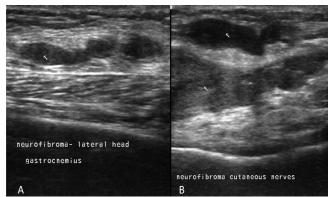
(A,B): High resolution ultrasound of both legs showing thickening of cutaneous and muscular nerves due to mixed echoic neurofibromas.
